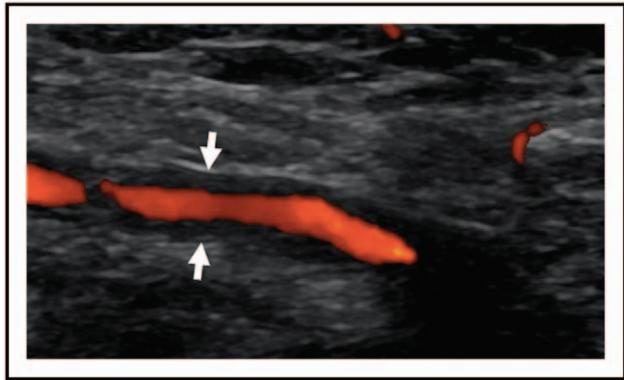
Temporal artery ultrasound with doppler demonstrating the halo sign. Ultrasound demonstrating a longitudinal view of the left superficial cutaneous temporal artery. The halo sign is indicated by the white arrows and is demonstrated as a hypoechoic lining around the artery.
